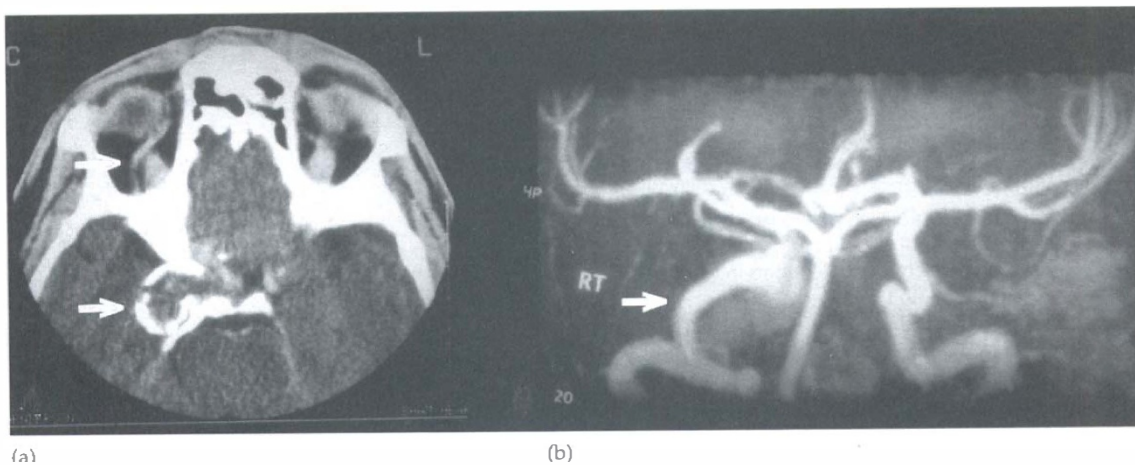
(a) CT scan showing a large partially calcified lesion within the right cavernous sinus (lower arrow). The right superior ophthalmic vein is dilated (upper arrow). (b) Magnetic resonance angiography showing a saccular aneurysm of the intracavernous portion of the right internal carotid artery. The upper right internal carotid artery is being displaced by the aneurysm (arrow). The left internal carotid artery is normal.
